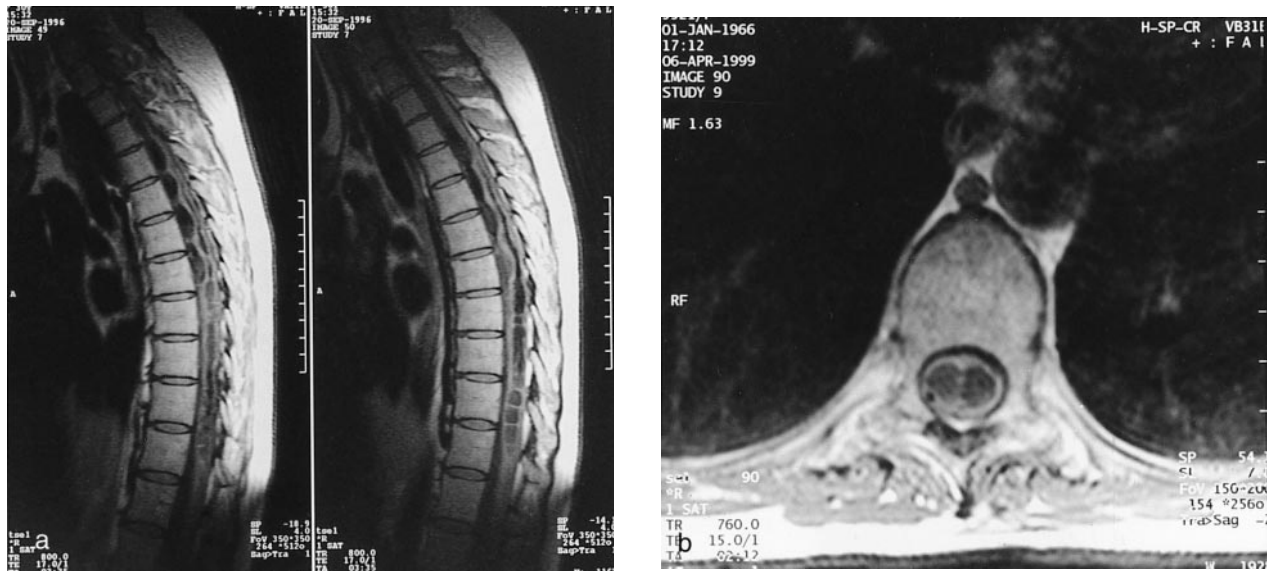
On T1W (TR 800, TE 17) sagittal (a), and (TR 735, TE 15) axial (b) MRI scan of the thoracic spine showed a syrinx cavity extending from T₃ to T₁₀. Band like structures separates the cavity and attaches the spinal cord to the dura
